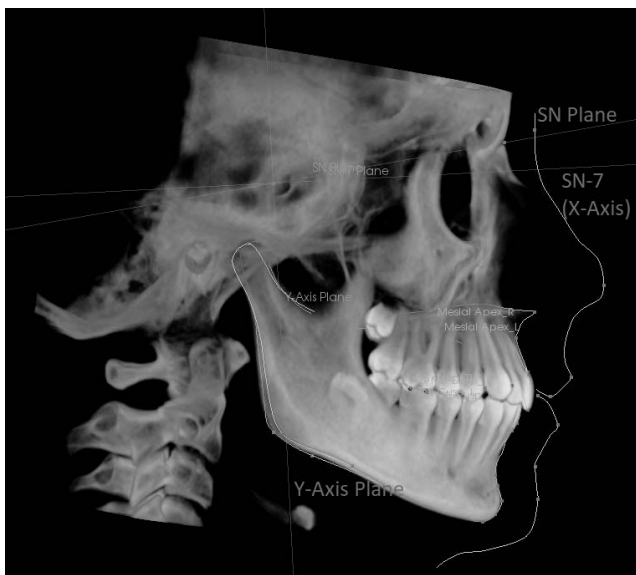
Cone beam computed tomography analysis in the AP and vertical dimensions.
